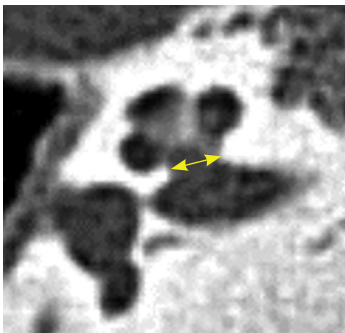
HRCT temporal bone, axial view, bone window shows the measurement of the cochlear aperture (BCNC) at mid-modiolar level.
